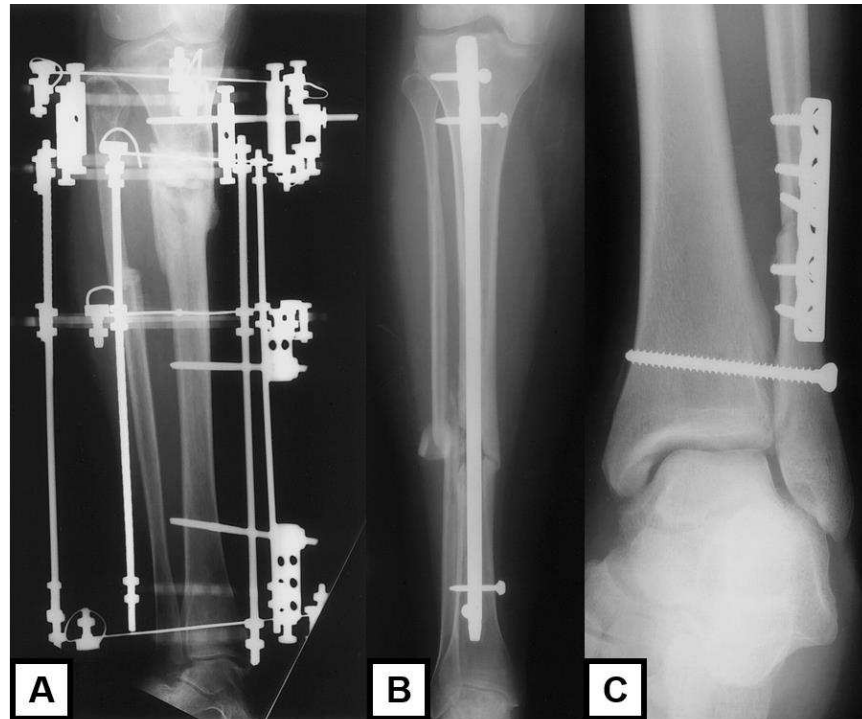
X-ray imaging comparison of lower leg fractures treated by A) external fixation, B) intramedullary nailing, and C) plating fixation techniques. (Reprinted with permission from Radiological Society of North America, [73] [Taljanovic, M.S., et al., Fracture Fixation. RadioGraphics, 2003. 23\(6\): p. 1569-1590](#)).
